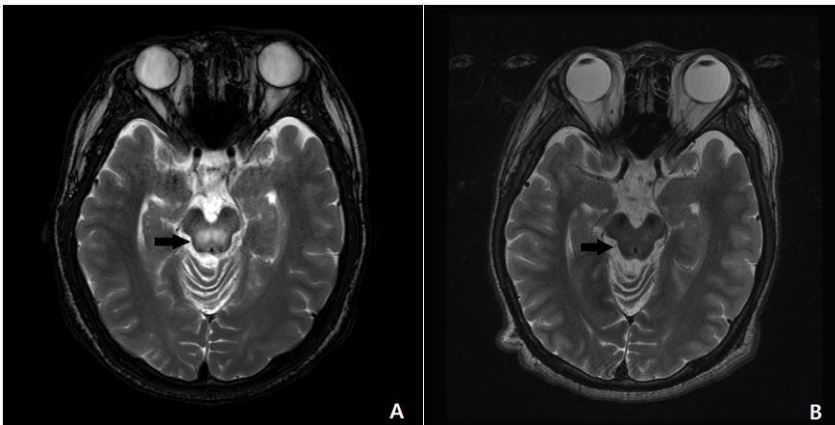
One year follow-up of brain MRI. Initial brain MRI shows high signal intensity (black arrow) in pons and midbrain (A, February 2, 2016). With the treatment of D-penicillamine, 1-year follow-up brain MRI shows decreased signal intensity (black arrow) in the pons and the midbrain (B, January 10, 2017).
